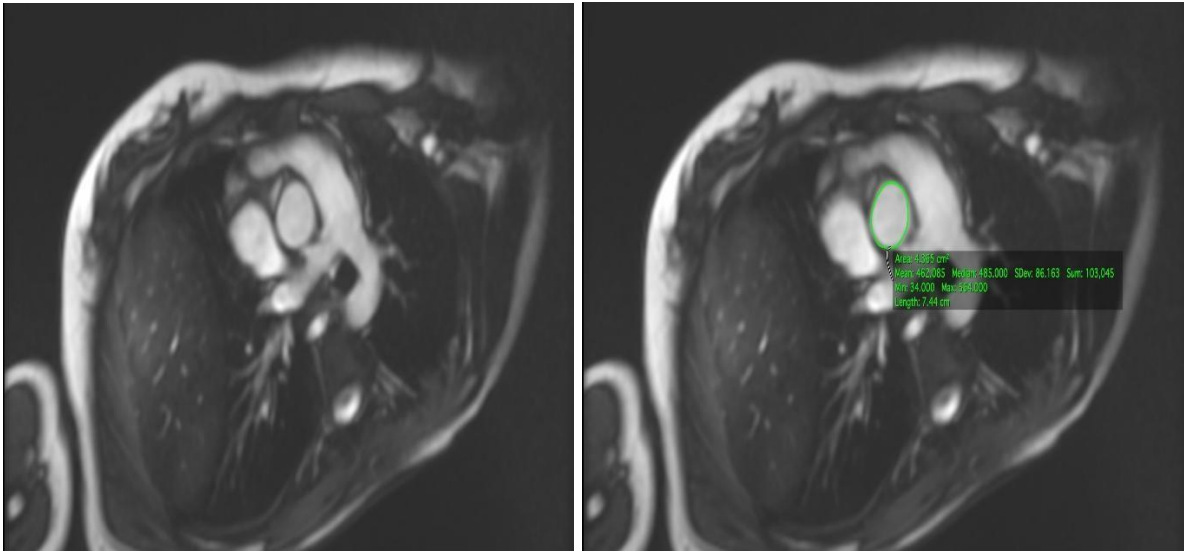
(left): cardiac MRI axial image of ascending aorta of the same patient during diastole and figure 2a (right): traced aortic circumference showing smaller area.
